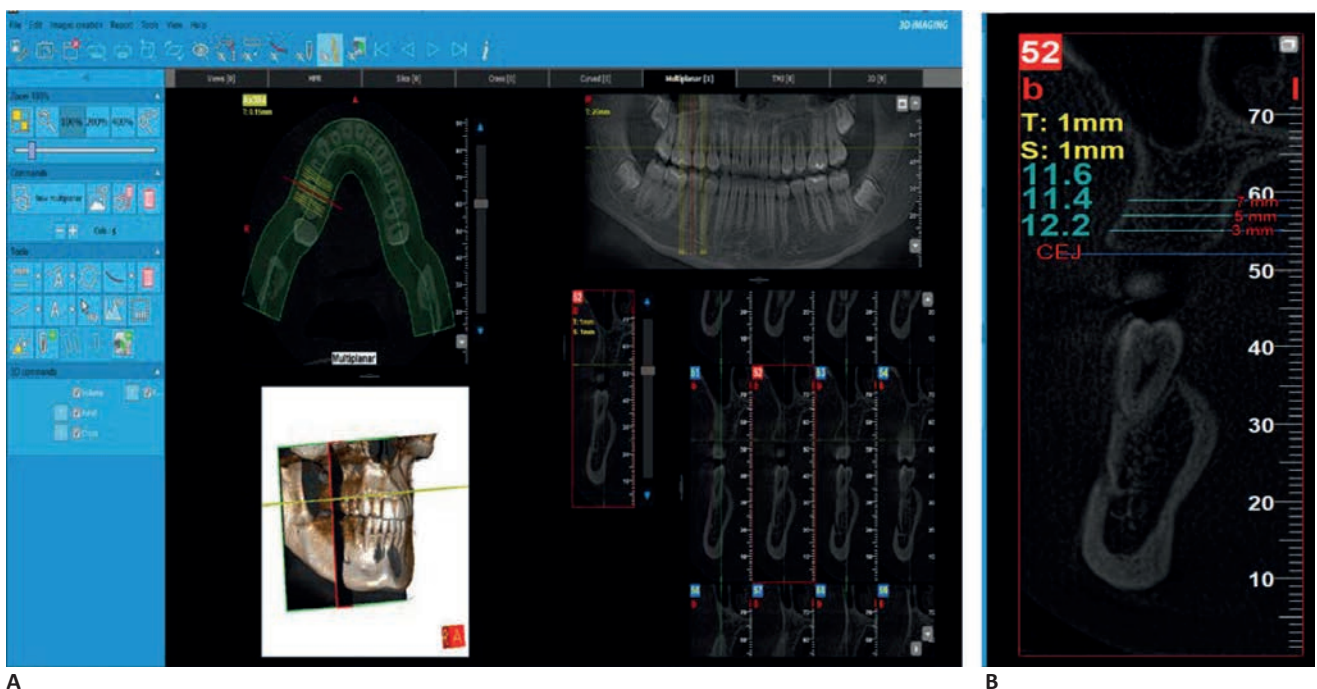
NewTom's NNT software for CBCT images. (A) showed four views include: Axial, Panoramic, Sagittal and 3D rendering images; (B) Bone thickness measured in sagittal view at 3,5 and 7 mm from cemento-enamel junction
